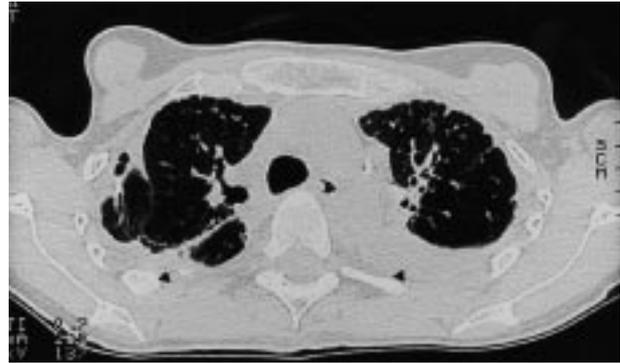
Thoracic computed tomography from patient 3 performed while she was asymptomatic, showing bilateral apical pleural thickening more marked on the left side (arrow heads.)
